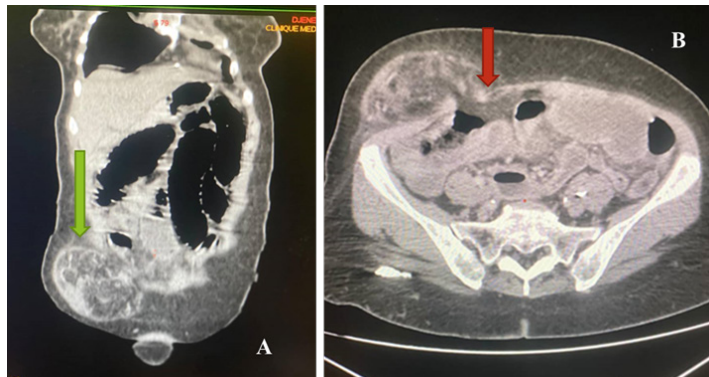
(A and B): Abdominal CT scan with coronal (A) and axial (B) reconstruction showed a dehiscence with 19 mm continuity at the level of the abdominal wall of the right iliac fossa with epiploid and intestinal contents.
